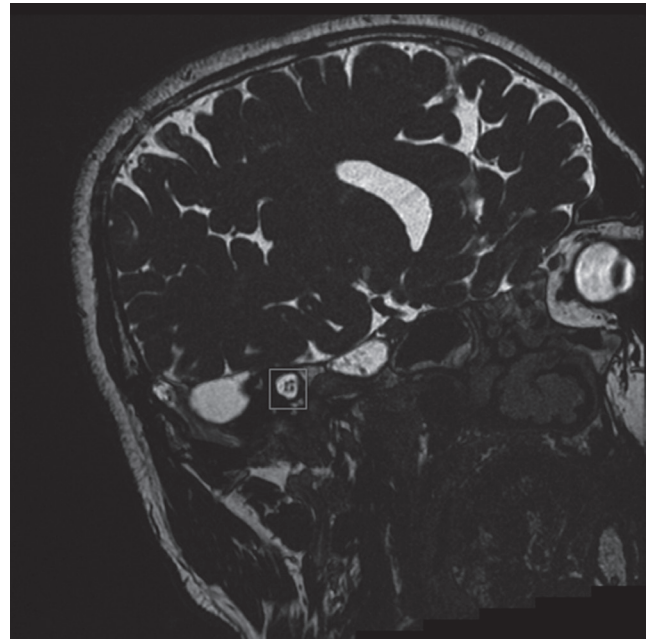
A sample magnetic resonance image and selection region of interest including internal auditory canal and its content.
